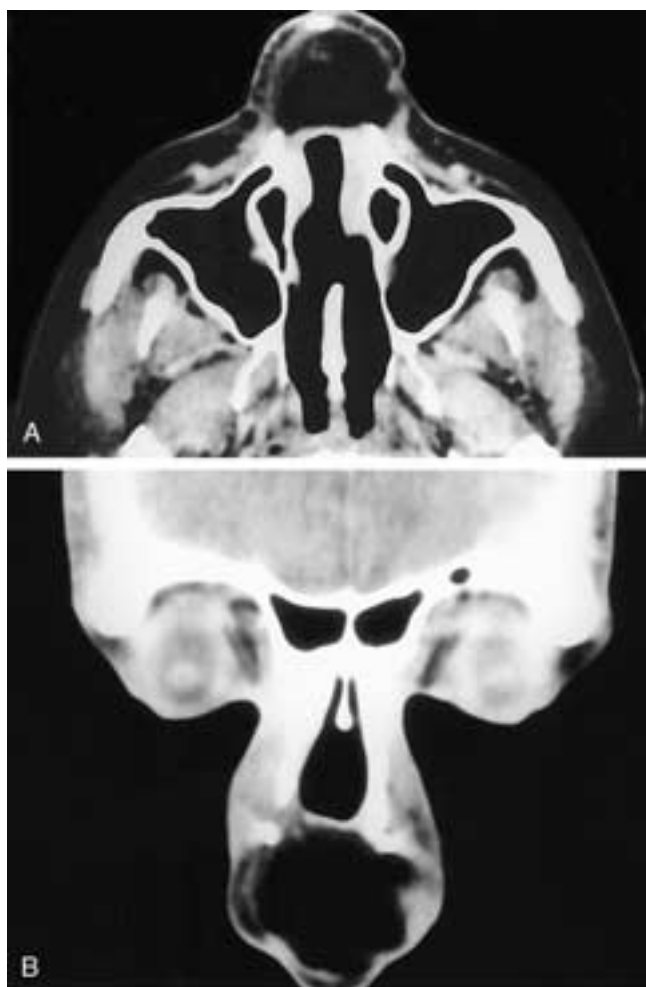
Axial (A) and coronal (B) CT scans show a free flap reconstruction of the lower nose after a rhinectomy. The bulk of the graft is fatty.
